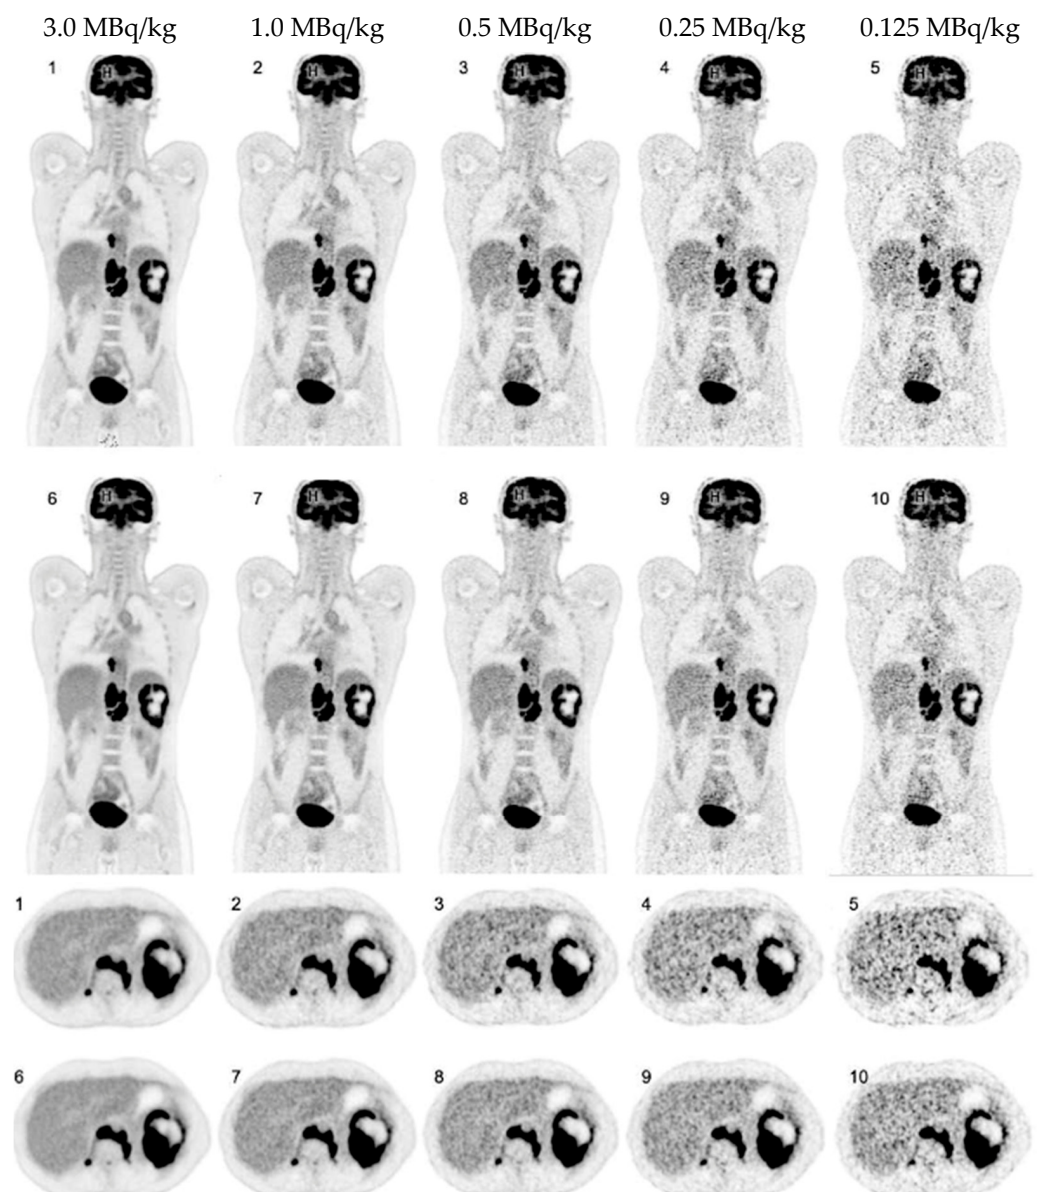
Coronal and axial [¹⁸F]FDG PET images of a 37-year-old patient with Hodgkin lymphoma reconstructed in high-sensitivity (1–5) and ultra-high sensitivity (6–10) mode.
